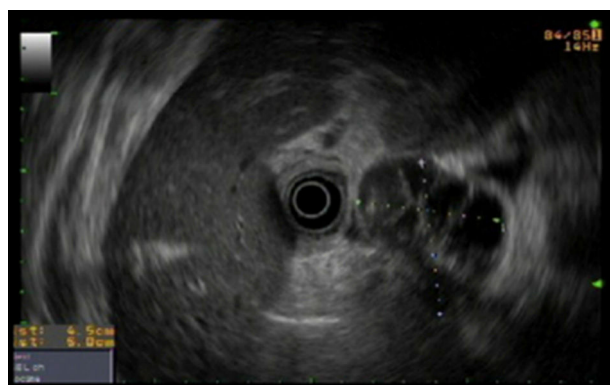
Endoscopic ultrasound: hypoechoic and heterogeneous pancreatic cystic lesion measuring 5 × 4 cm.
